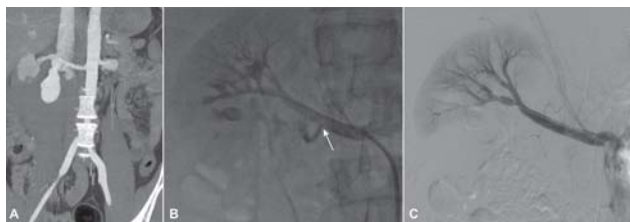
(A) CT angiogram shows a post-traumatic pseudoaneurysm and an arteriovenous fistula following a stab wound. (B) Fluoroscopic image showing exact location of fistula (white arrow). (C) No active extravasation or early venous filling was seen on the final angiogram.
